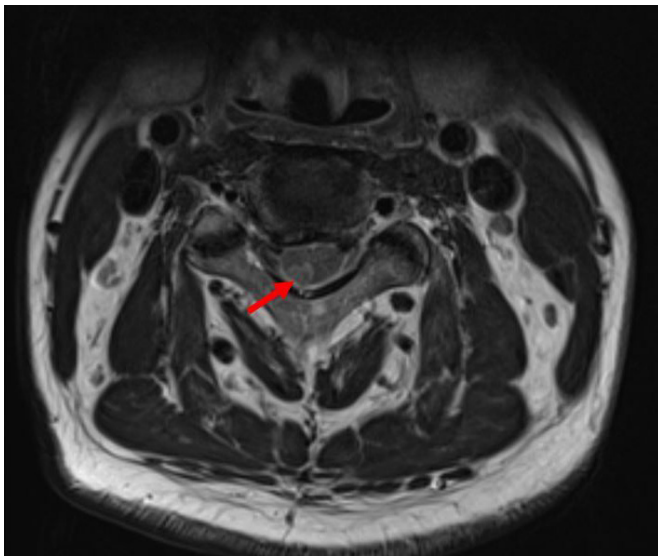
Image showing the nodular enhancement of right C3–C4 level (arrow) on axial T2 weighted magnetic resonance imaging.
